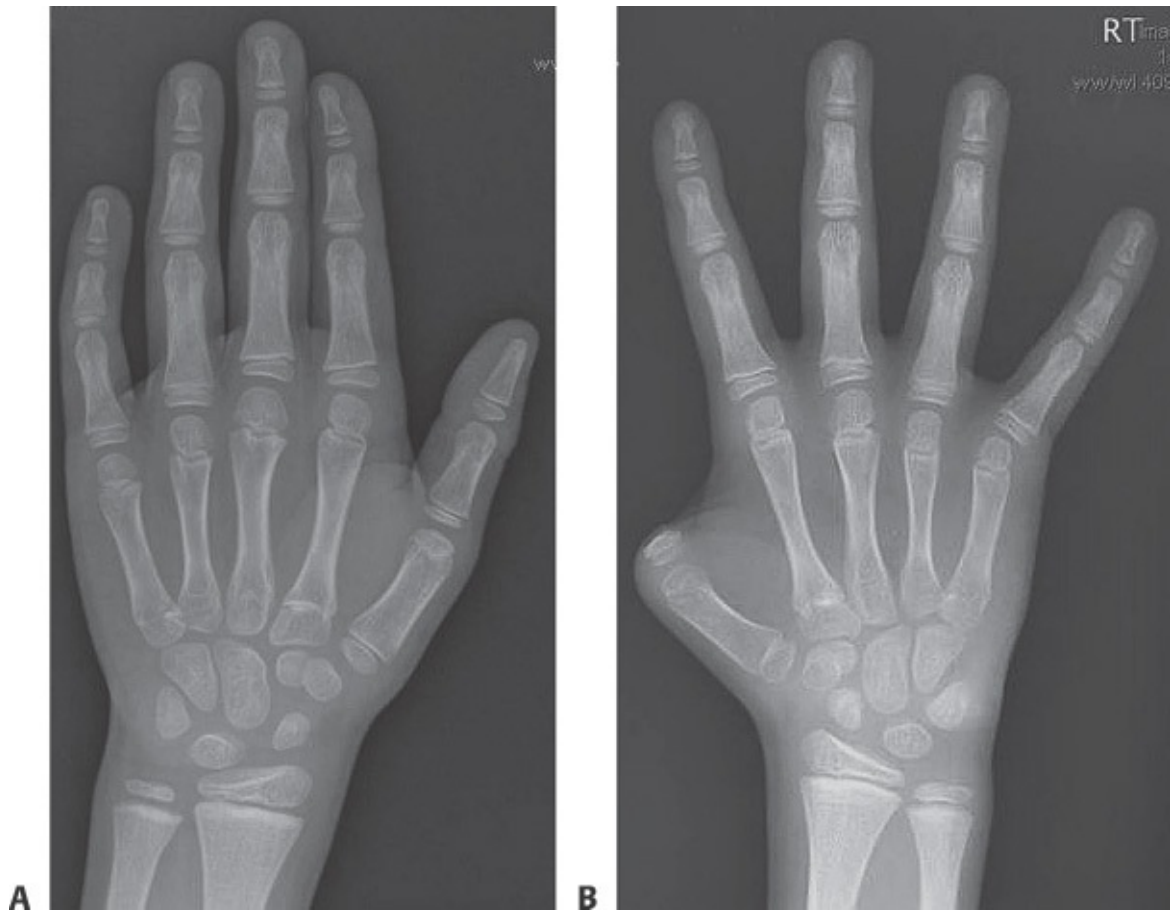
• Preoperative radiograph of recipient hand. Amputation level is at the proximal phalanx base. Contralateral radiographs help estimate defect length.
